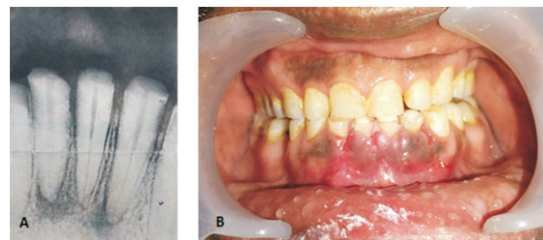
Pre Treatment Radiograph (iopar) And Intraoral Picture
